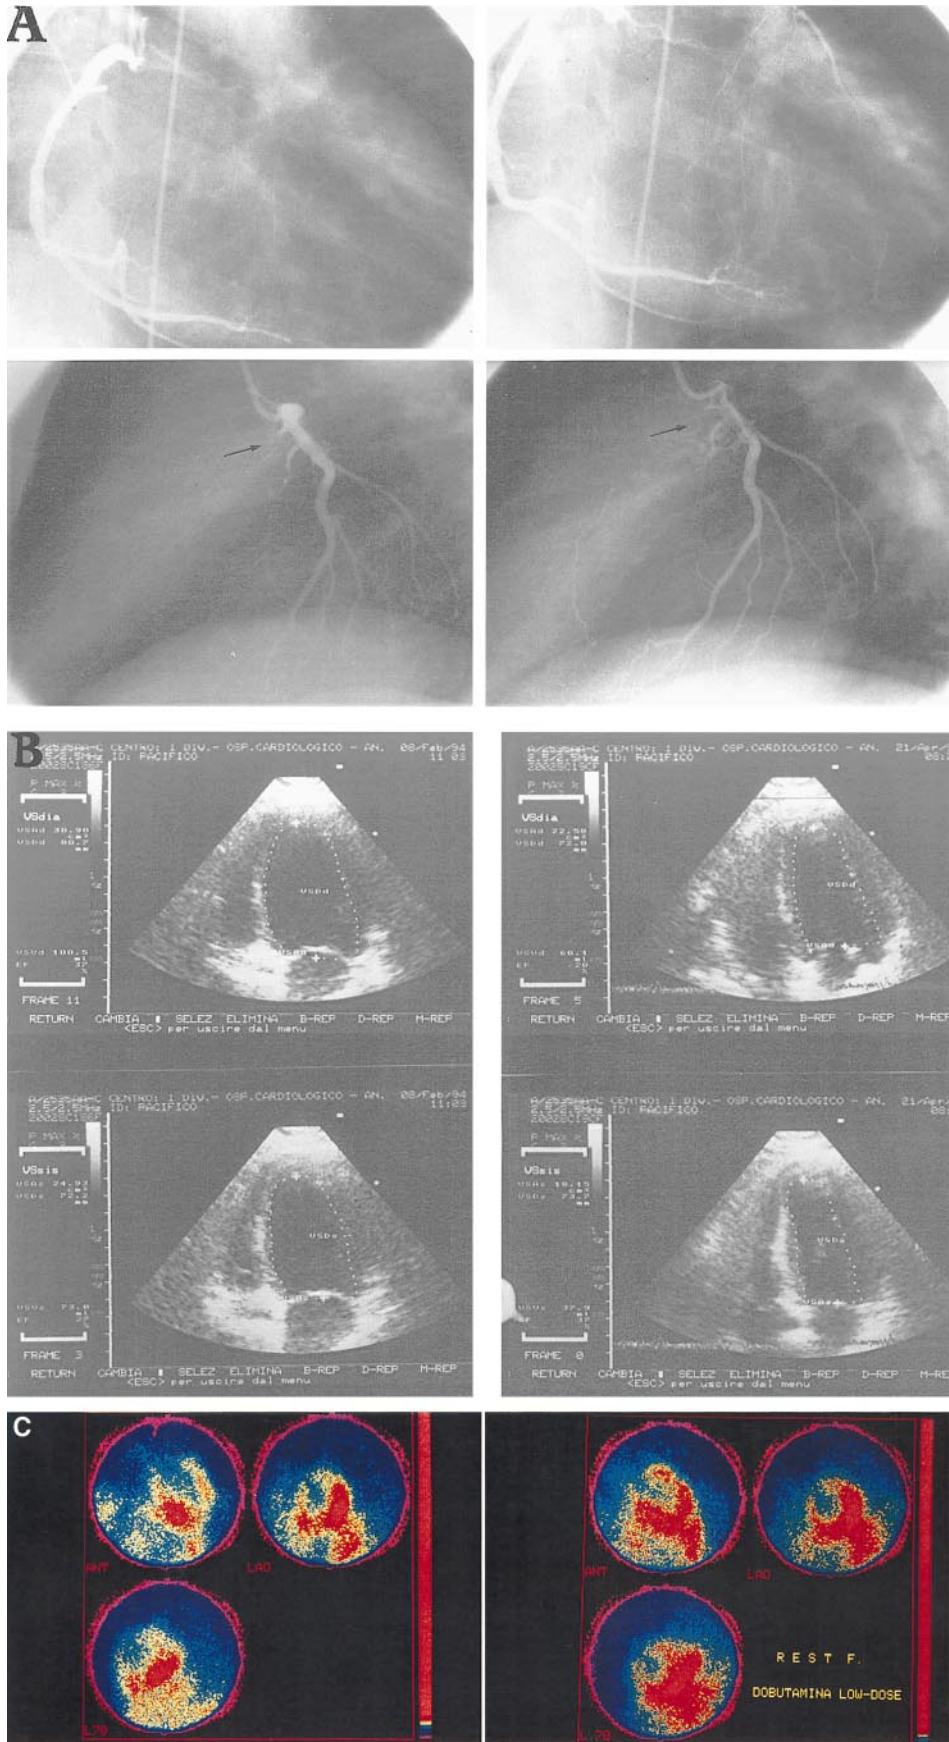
A 49-year-old man with a prior (7 month) anterior myocardial infarction and depressed left ventricular systolic function (resting ejection fraction, 28%). A (left), Baseline coronary angiogram in right anterior oblique (top) and left lateral (bottom) projections. The right coronary artery (RCA) is normal. In both images there is no opacification of the left anterior descending artery (LAD) due to total occlusion of its first tract. Collaterals were scarcely developed from RCA to LAD. A (right), After exercise training, evident collaterals developed from RCA to LAD, partly through the septal branches (top panel). On left lateral projection (bottom panel), the occlusion of the first tract of LAD was unchanged from the baseline study. B, Dobutamine stress echocardiography at baseline (left side: end diastole, top panel; end systole, bottom panel) and after training in apical four-chamber view. Images were taken at peak dobutamine infusion. At baseline, akinesis of apical anterior and inferior interventricular septum and apical, mid, and apical lateral segments was observed. After training, a reduction in end-systolic volume (-26%) (right side: bottom panel) as well as an improvement in the contractile response to dobutamine in all the above cited myocardial segments was observed. C, ²⁰¹Tl scintigrams from redistribution studies in the three standard projections at baseline (left panel) and after exercise training (right panel). On study entry, a marked reduction of thallium uptake was observed in the anterolateral, septal, and anterior segments. After training (bottom), an evident improvement in thallium uptake was observed in the basal and mid anterolateral segments.
